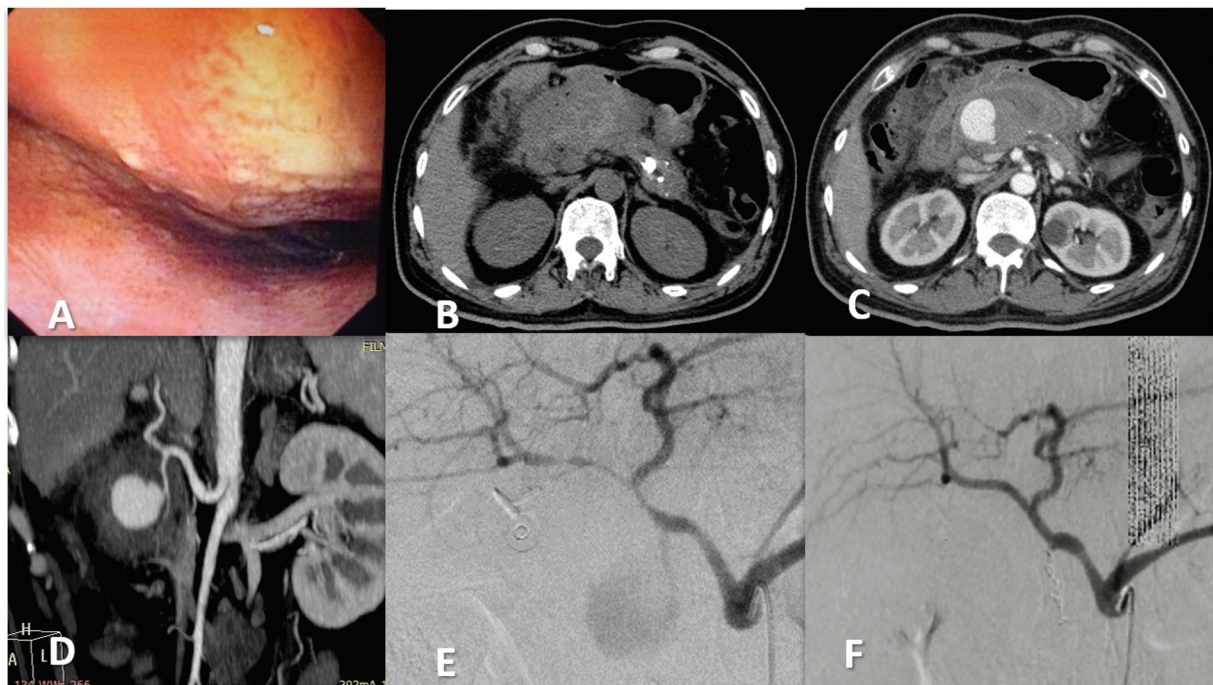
A 49-year-old man with severe upper abdominal pain and melena. (A) Upper gastrointestinal (GI) endoscopy showing compressive duodenal submucosal tumor-like lesion at the anterior wall of the duodenal bulb with a small ulcer on its surface. (B, C) Contrast-enhanced computed tomography (CECT) of the abdomen. Chronic pancreatitis with pseudoaneurysm within hematoma, which is abutting the duodenal bulb, head, and body of the pancreas. (D) CT coronal reformatted image showing pseudoaneurysm arising from the gastroduodenal artery. (E) Coeliac angiogram showing a pseudoaneurysm arising from the gastroduodenal artery and (F) after coil embolization of the same by the trap technique.
